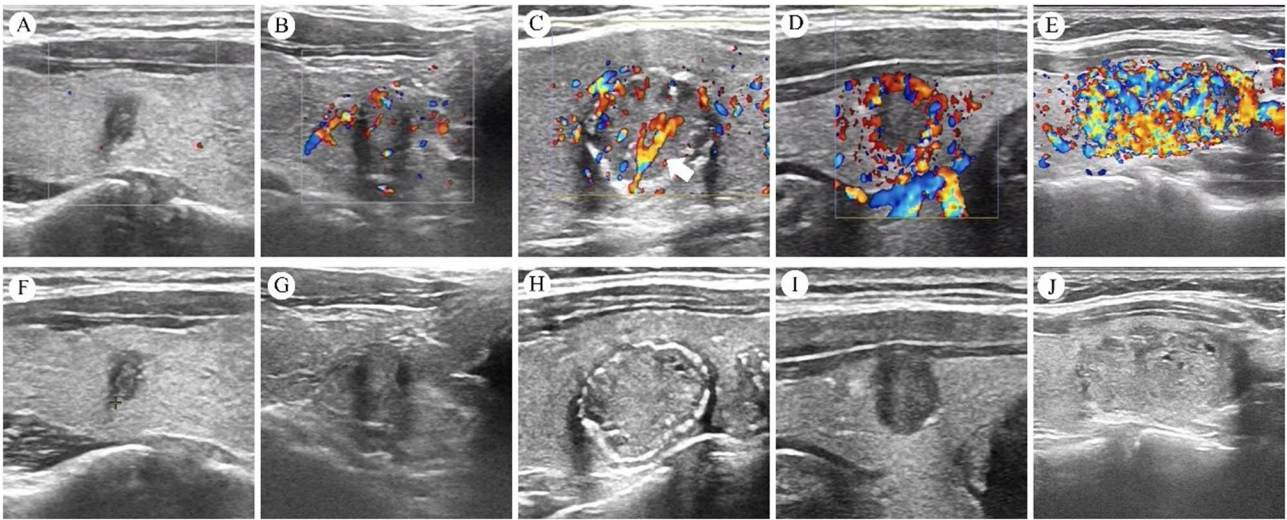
Color Doppler (top) and grayscale (bottom) ultrasound images of the five blood flow patterns. A avascular pattern showing no significant blood flow around or within the lesion. B dot-line pattern showing spot and short rod vessels around or inside the lesion. C branching pattern showing long blood vessels (indicated by white arrows), nearly or exceeding the lesion's radius, and extending the lesion in a radial arrangement. D garland pattern showing red and blue blood flow signals concentrated around the focal area, with no central blood flow. E rich-disorganized pattern showing dense red and blue blood flow signals visible, with disordered intratumoral vessels connected
